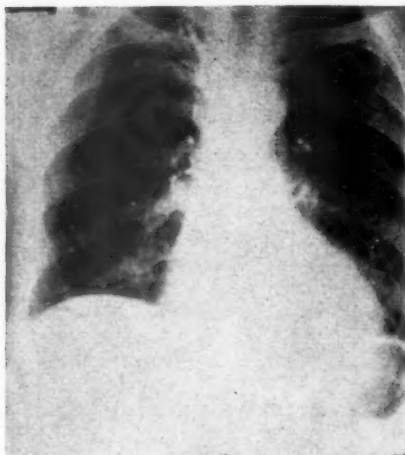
Post-operative chest X-ray—the diaphragm has descended.
